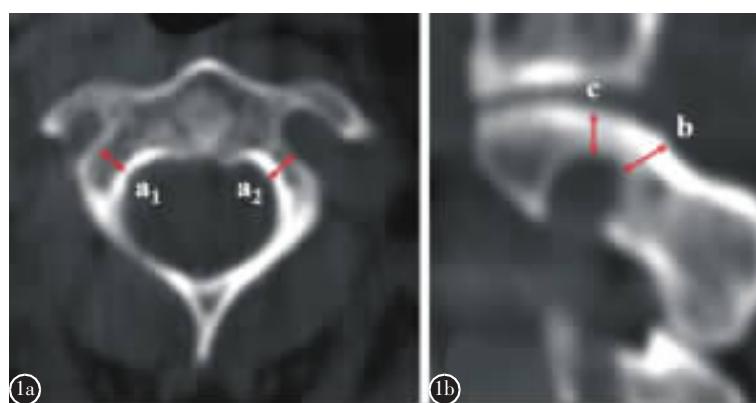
CT 测量枢椎椎弓根径线和判断椎动脉高跨变异(HRVA) a 1mm 薄层 CT 骨窗标准水平轴位图像(CT AXIS 测量法)测量枢椎双侧椎弓根髓腔宽度(a_1)及外径的宽度(a_2), $a_2 < 4\text{mm}$ 评估为不适合安全置入枢椎椎弓根螺钉 b 1mm 薄层 CT 骨窗正交矢状面测量枢椎双侧椎管内壁外侧 3mm 处的峡部高度(b)及侧块内高(c), $b \leq 2\text{mm}$ 或 $c \leq 5\text{mm}$ 判定为 HRVA, 评估为不适合安全置入枢椎椎弓根螺钉
